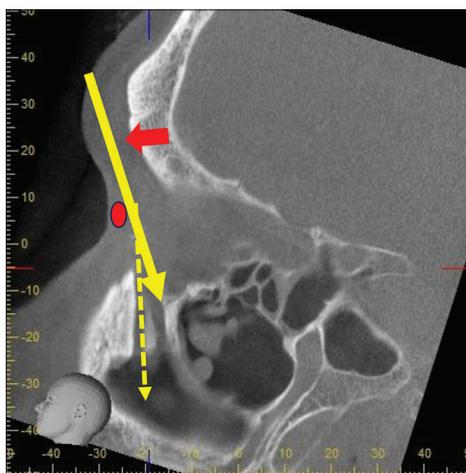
Sagittal computed tomography image. Probe trajectory (solid yellow arrow) is hindered by the superomedial orbital ridge (red arrow) and medial canthal tendon (red circle), causing misalignment between the probe and the duct inclination (dotted yellow line). Bending the probe is effective in overcoming this anatomical constraint
